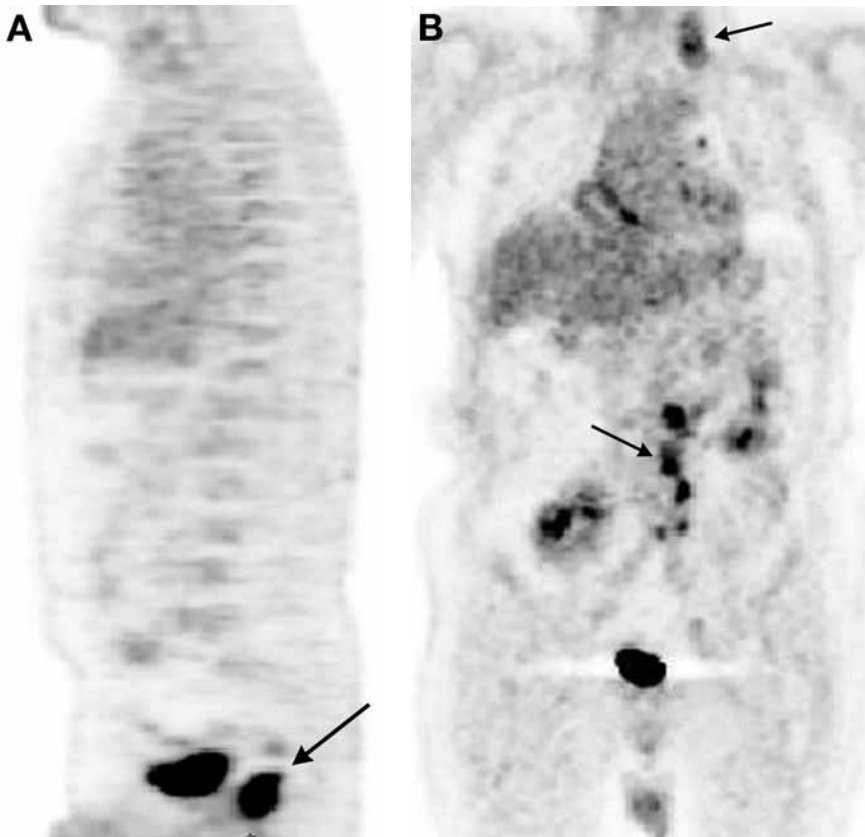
Sagittal positron emission tomography (PET) image (A) showing focally increased FDG uptake in the rectum (arrow) representing the primary tumor without evidence of uptake elsewhere. Another patient (B) with diffuse nodal metastases seen on a coronal PET image.
